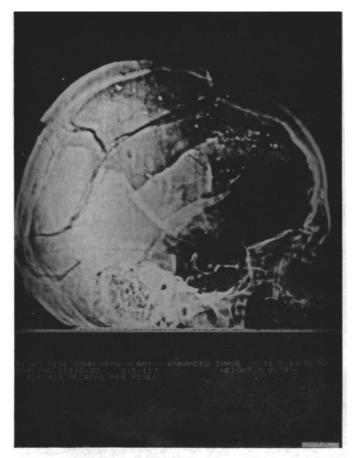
Photograph of a computer-assisted image enhancement of a lateral X-ray of the skull (autopsy X-ray No. 2).
